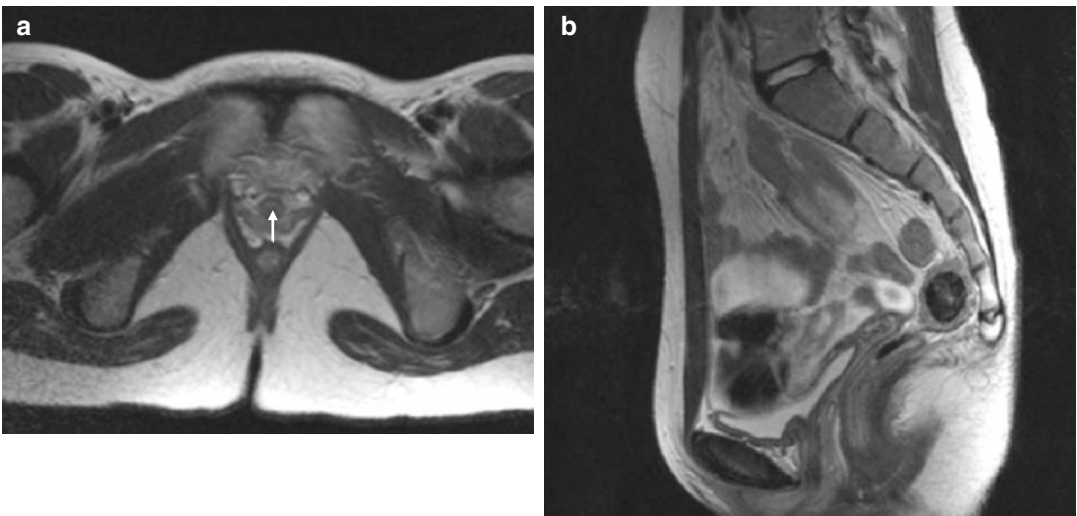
Uterine hypoplasia (I). Fast spin-echo T2-weighted images on axial (TR/TE 3000/108) (a) and sagittal plane (TR/TE 3310/94) (b) show uterine hypoplasia. Small uterine
